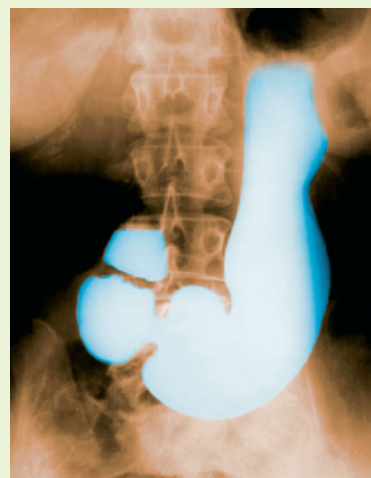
■ A barium x-ray of a healthy stomach
